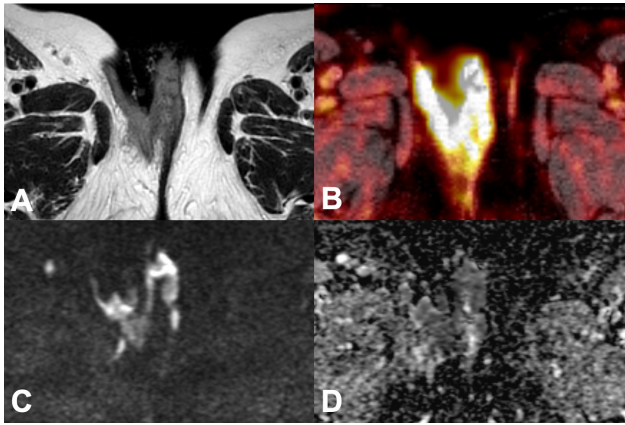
Axial T2(A), FDG-PET/CT (B), DWI(C) and ADC map (D) shows an intermediate, T2w signal intensity mass centred on the right labia majora extending into the upper inner aspect of the thigh. The mass is high signal on the diffusion weighted imaging and low signal on the ADC map in keeping with tumour. It is markedly avid on FDG-PET/CT (SUV max 16.6).
